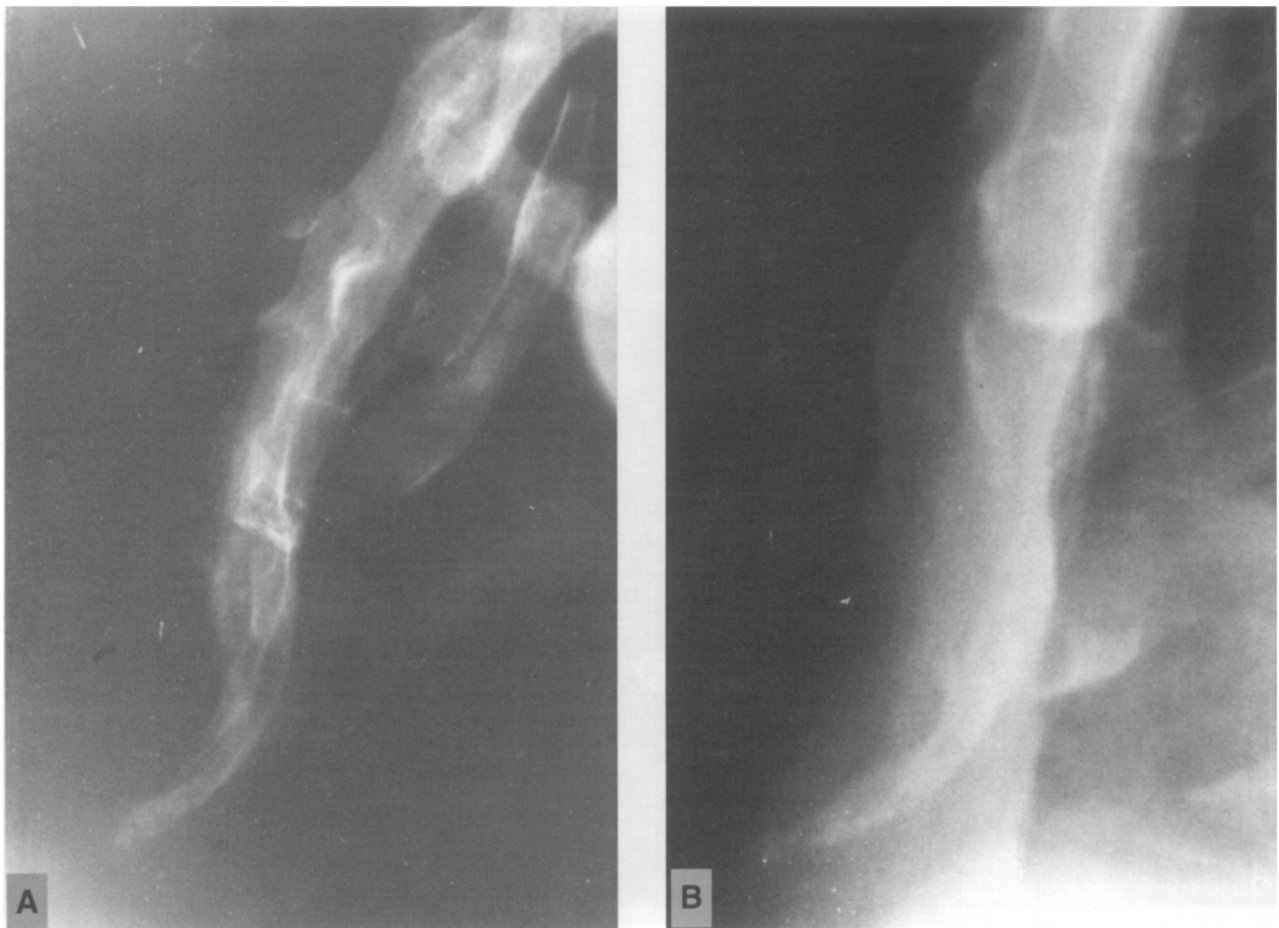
(A) Antemortem: everted xyphoid process as seen on lateral-medial plate of chest. (B) Postmortem: same anatomic variant seen on X-ray of the recovered victim.
